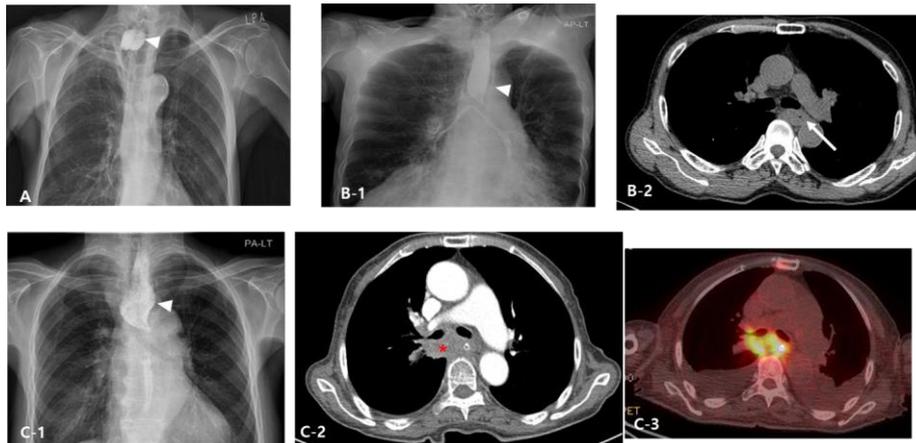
Chest roentgenogram which was taken after videofluoroscopic swallowing studies in 3 cases with obstructive esophageal dysphagia due to malignancy shows severe dilatation (arrow head) in cervical (A) and upper thoracic (B-1, C-1) esophagus. Two patients had been diagnosed as esophageal cancer and received bypass operation due to esophageal cancer in 5 years ago (A) or chemotherapy (B-1). Segmental circumferential wall thickening was noted in the mid esophagus (B-2). The third case who suffered from poor oral intake presented for unexplained swallowing difficulty. After videofluoroscopic swallowing study, severe esophageal dilatation is observed at upper thoracic level (C-1, arrowhead) in chest roentgenogram. The esophagus with nasogastric tube is compressed by metastatic lymph nodes (C-2, asterisk) with hypermetabolism in PET (C-3).
